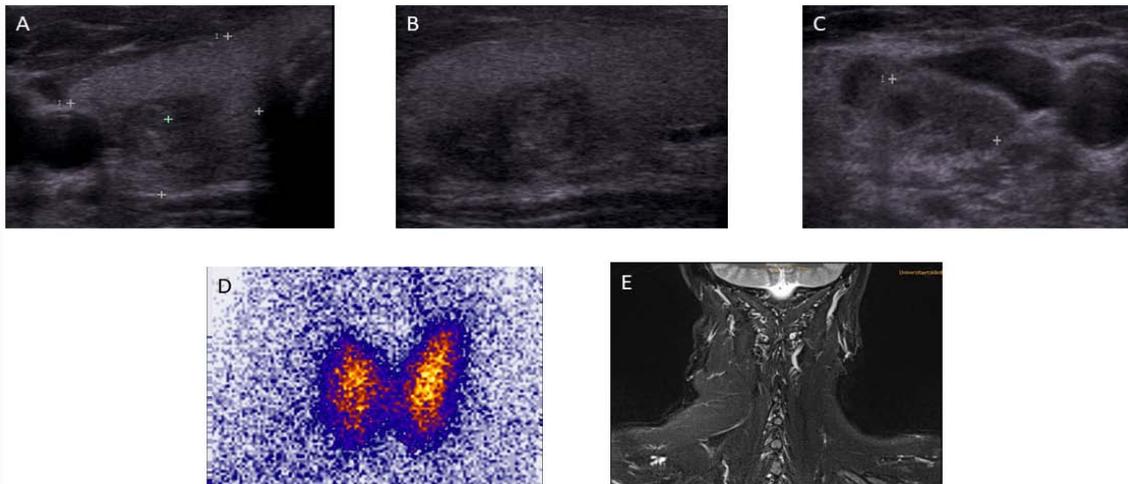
Initial diagnosis 2014: (A, B) ultrasound of thyroid node. (C) Ultrasound of cervical lymph node. (D) Thyroid scintigraphy. (E) Magnetic resonance of neck.
